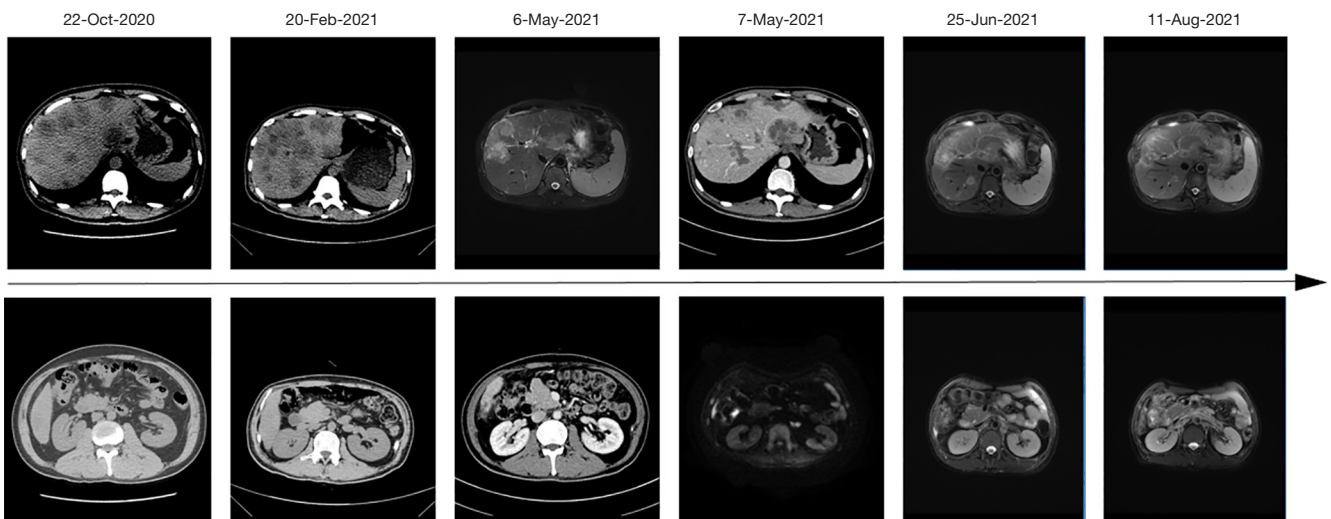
Computed tomography and the magnetic resonance imaging scans identified primary colorectal cancer and liver metastases after different treatment regimens.
